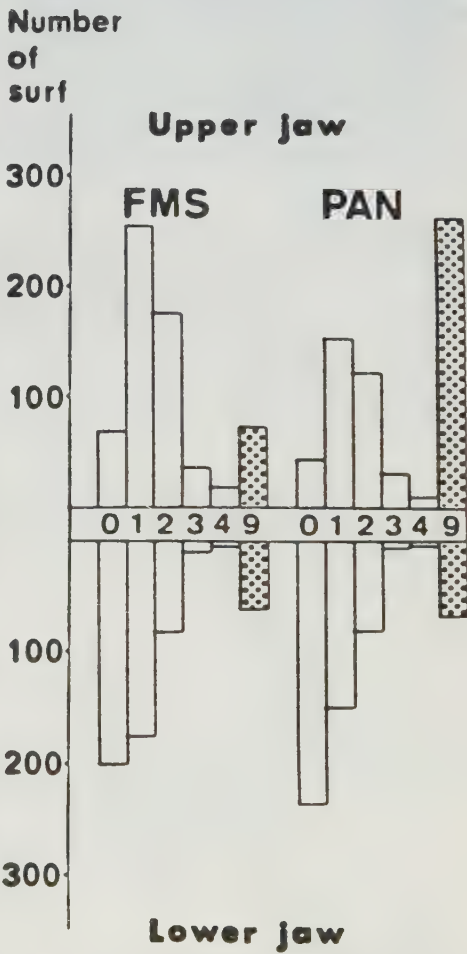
The distribution of different bone score units (value 0-4) on mesial and distal surfaces for the posterior regions in full mouth surveys (FMS) and panoramic radiographs (PAN). 9 = non-measurable.
